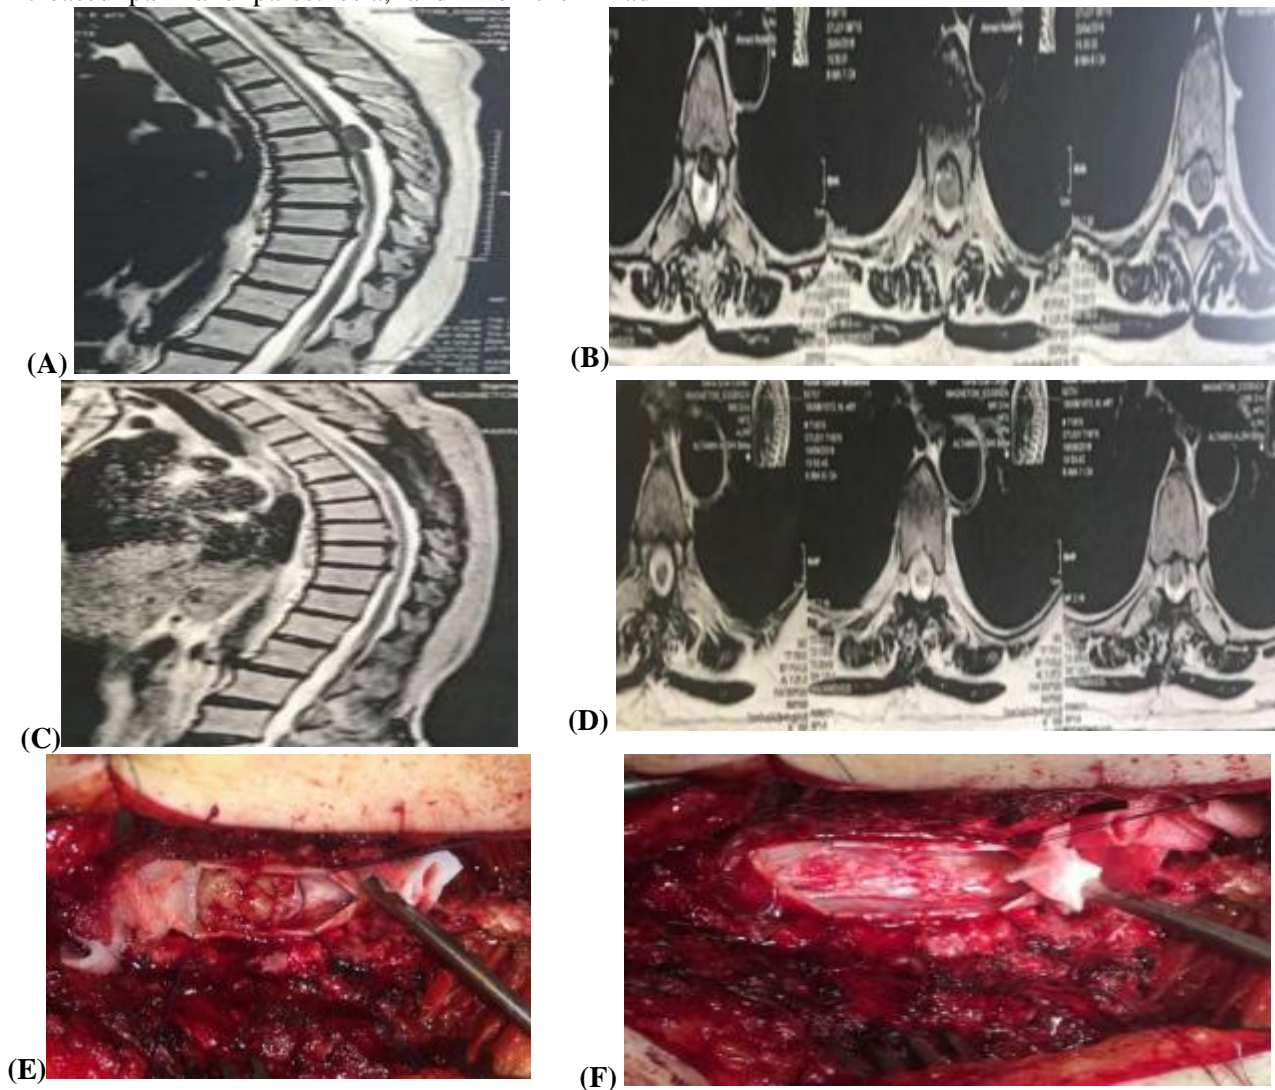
A 48 years old female patient who had surgery for lumbar spondylolisthesis, she had initial improvement before she developed new symptoms after 1 year of surgery. She had recurring severe lower back pain (VAS 10) but with LL spasticity and hyperreflexia, then she had progressive LL weakness to grade 3 right side and grade 4- left side (Frankel grade C) and sphincteric dysfunction. MRI thoracic spine revealed IDEM tumor at D6 level with severe cord compression. Surgery was done with laminectomy, complete tumor excision was done. Postoperatively, patient had improved to full power bilaterally (Frankel grade E). she had full sphincteric control, and the lower back pain improved to VAS 1. [A-D: MRI dorsal spine, pre-operative (A, B) and post-operative (C, D), E, F: intra-operative images show pre IDEM tumor excision (E) and post excision (F)].
